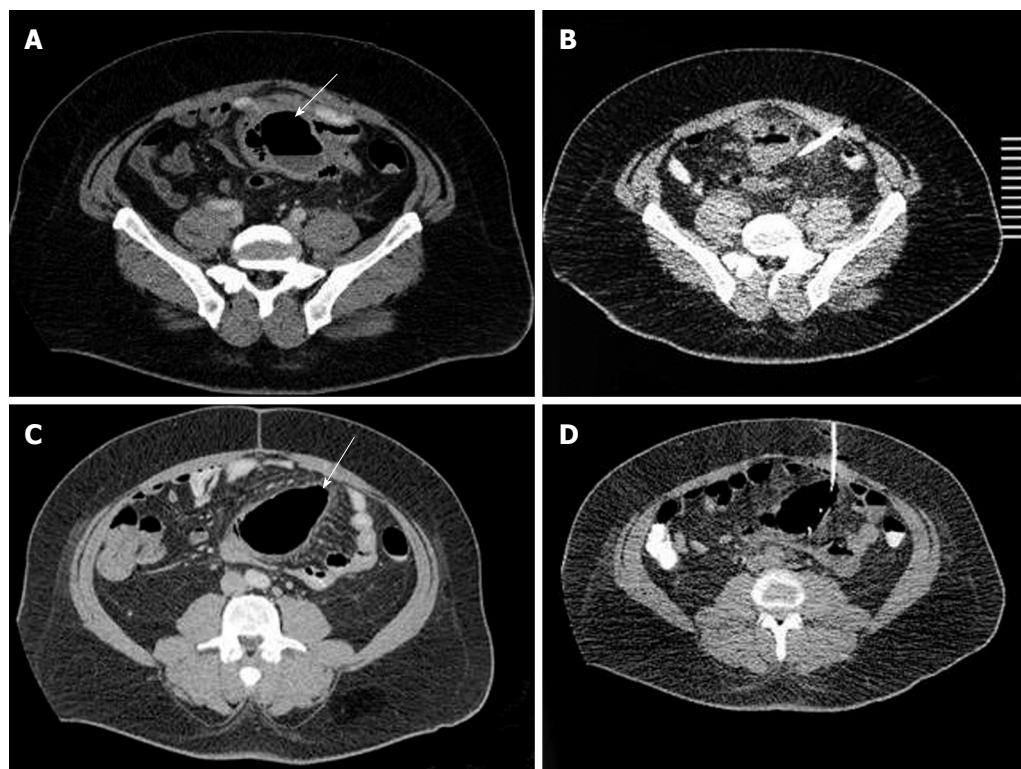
Sigmoid diverticulitis complicated by pericolic abscesses (A and C, arrows) requiring treatment by placement of two separate CT-guided percutaneous drains (B and D). This patient underwent laparoscopic sigmoidectomy with primary colorectal anastomosis and removal of both drains 6 wk after percutaneous drain placement.
